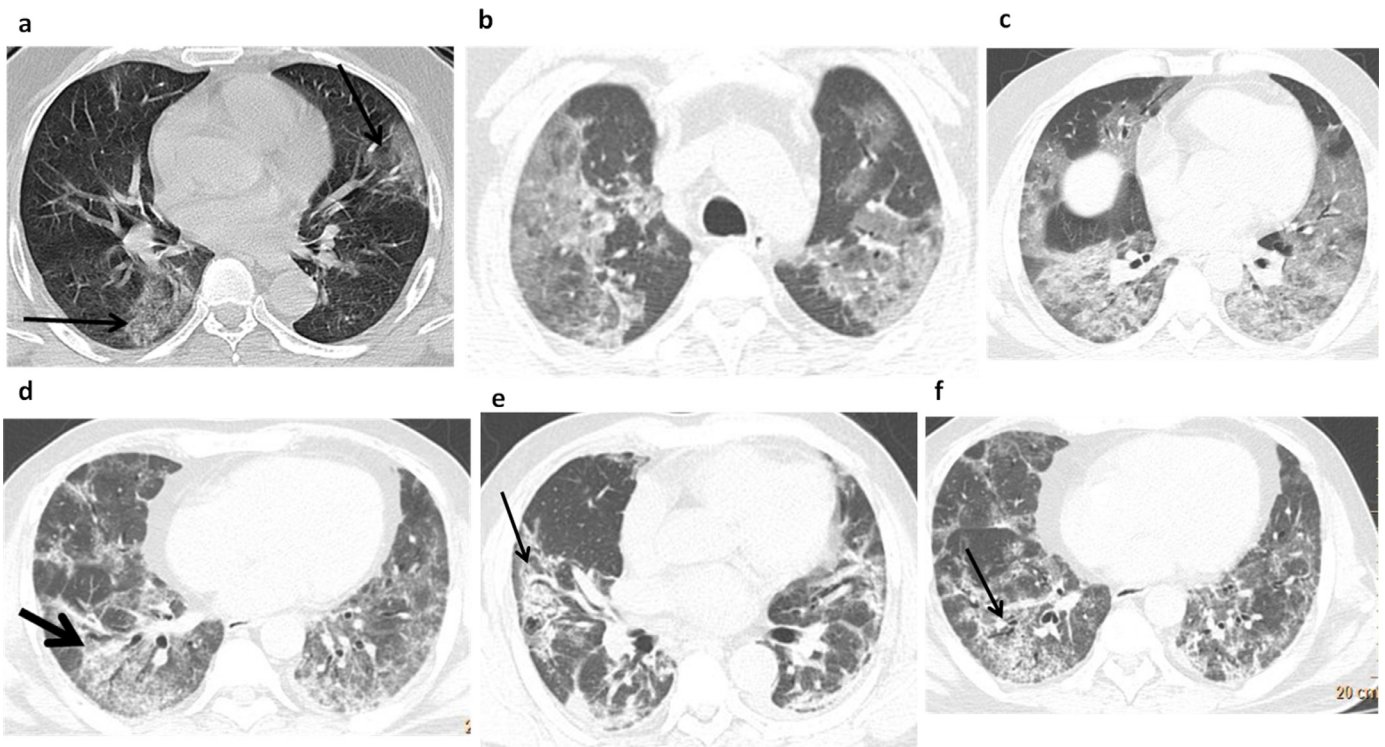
Typical chest CT findings of COVID-19 pneumonia in different patients. Axial CT images reveal (A) Early findings of peripheral rounded GGO (B, C) bilateral peripheral and lower lobe confluent GGO. Other commonly noted signs are (D) air bronchogram (arrow), (E) vascular enlargement (arrow), and (F) crazy paving (arrow).
